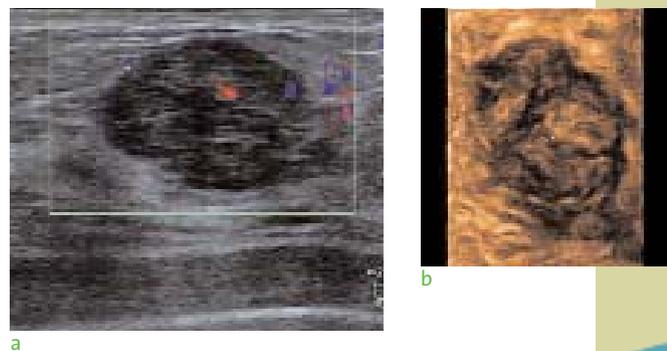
Predominantly smooth bordered lesion (a); C-plane of a 3D ultrasound (b): Compression pattern: BI-RADS 3; monitoring recommended
